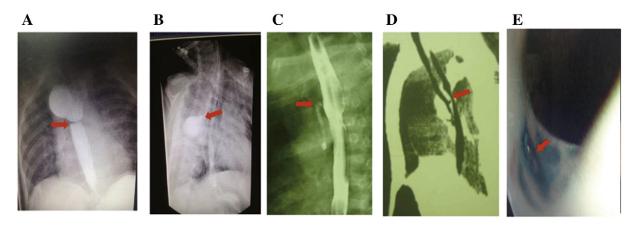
Diagnosis of anastomotic complications. A. Esophagogram showing an anastomotic stricture (red arrowhead). B. Esophagogram showing an anastomotic leakage (red arrowhead). C. Esophagogram showing a recurrent tracheoesophageal fistula (red arrowhead). D. Three-dimensional reconstruction of chest CT, revealing a recurrent tracheoesophageal fistula (red arrowhead). E. Esophagoscopy revealing a recurrent tracheoesophageal fistula dyed by methylene blue (red arrowhead).
